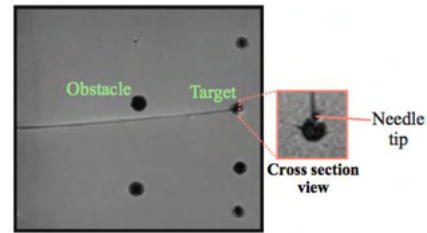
A coronal magnetic resonance image of one representative insertion. The inset figure shows the cross-sectional view of the final needle tip position.
